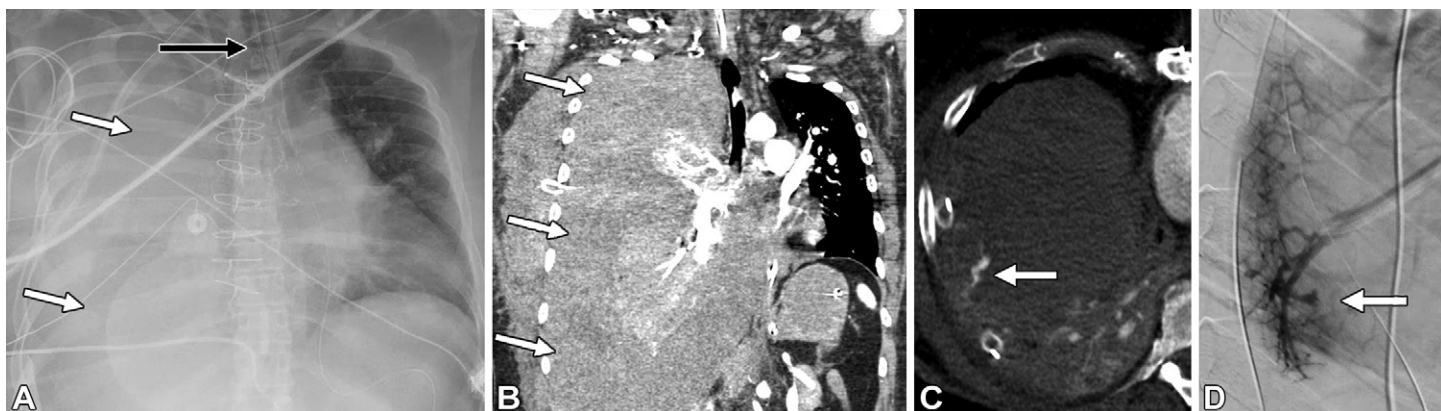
Pulmonary artery injury in a 57-year-old woman with CTEPH after BPA. (A) Chest radiograph 9 hours after BPA shows complete opacification of the right hemithorax (white arrows) with tracheal deviation to the left (black arrow), consistent with a large right pleural effusion concerning for hemothorax. (B) Coronal CT image 13 hours after BPA shows a large right hemothorax (arrows). A source was not definitively identified, and the patient was taken to the operating room, where a right lower lobe parenchymal injury was identified. Despite this, the patient developed recurrent hemothorax. (C) Axial delayed phase image from repeat CT angiography shows active extravasation (arrow) from a subsegmental branch of the anterior basal right lower lobe pulmonary artery. (D) Catheter pulmonary angiogram shows active extravasation (arrow) from the subsegmental vessels, which were subsequently embolized.
